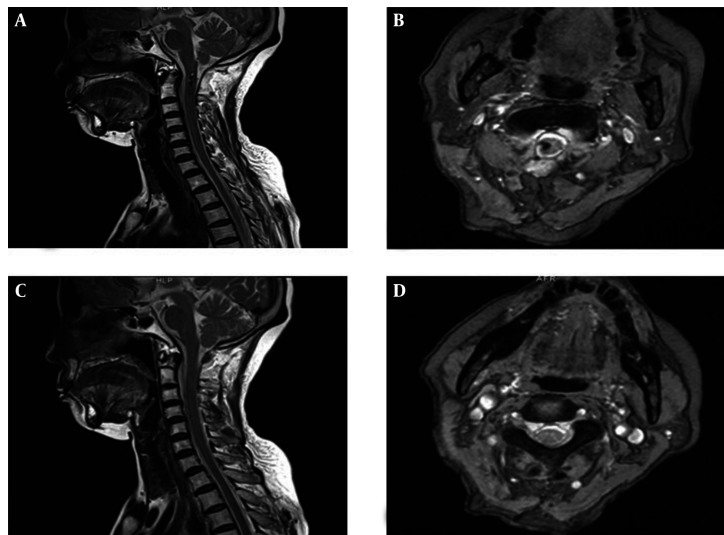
The area of the lesion, which was completely resected, is shown on the sagittal T2-weighted images (A) and the axial T2-weighted images (B) postoperatively. No lesion recurrence was observed on sagittal T2-weighted images (C) or axial T2-weighted images (D) after one year of follow-up.
